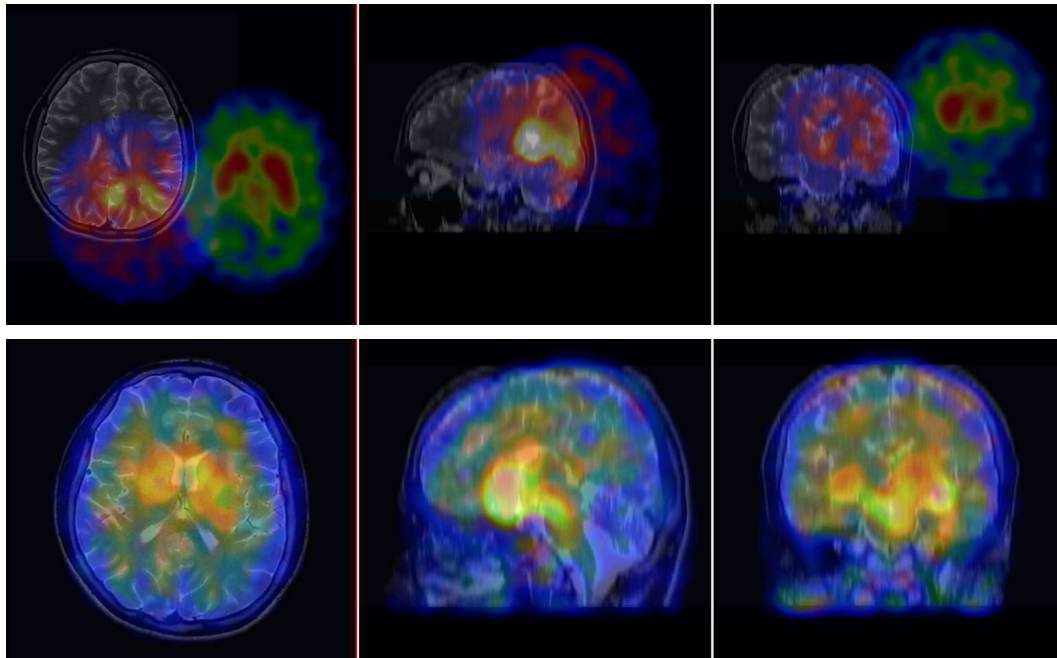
A real medical IBZM SPECT-Datscan SPECT-MRI example representing the initial stage (top) and the result provided by our framework applying the PF sampling strategy (bottom).
